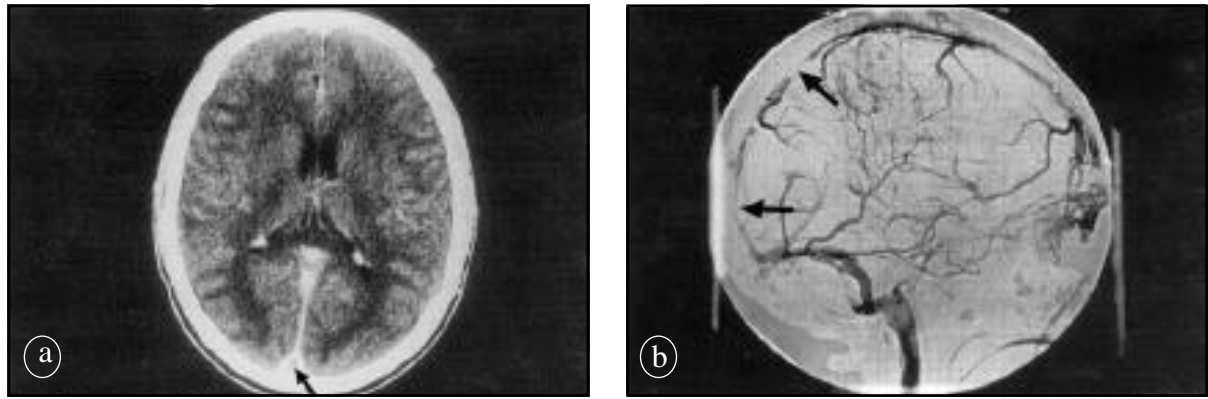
A 29-year-old male patient with neuro-Behcet disease and cerebral venous thrombosis. a) Axial contrast enhanced CT brain showing filling defect in the posterior part of superior sagittal sinus (SSS) giving the appearance of "empty delta" sign, (arrow). b) Lateral view of venous phase of right internal carotid arteriogram showing poorly opacified SSS with multiple filling defects (arrows) due to sinus thrombosis.
